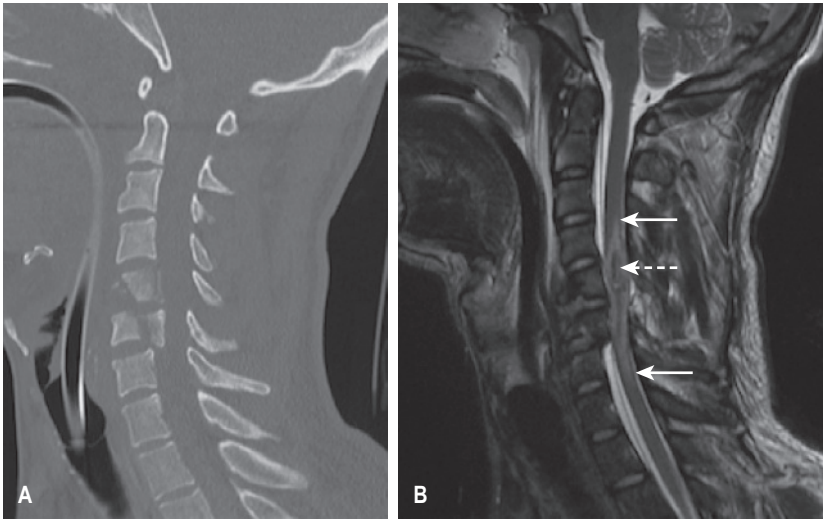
Cord Contusion. (A) Sagittal computed tomography of the cervical spine shows fractures of the C5 and C6 vertebral bodies, with associated retropulsion. (B) Sagittal T2-weighted magnetic resonance imaging demonstrates a cord contusion extending from C4 to C7 (solid arrows) and a focus of haemorrhage within the cord at C5 (dashed arrow).
